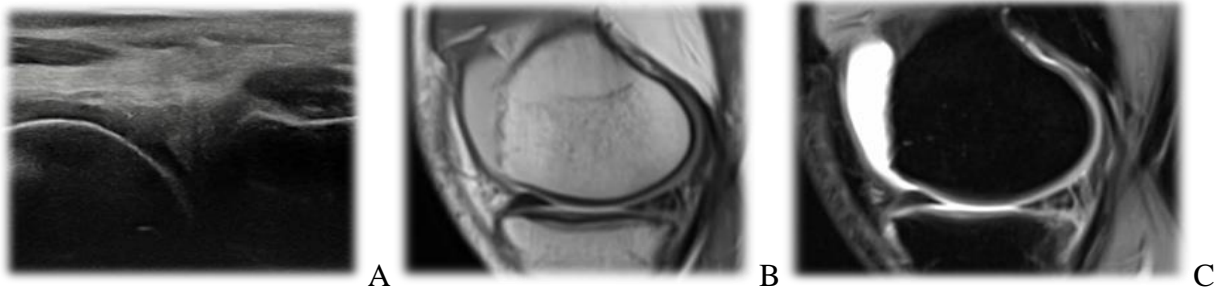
A US images of PHMM tear, B, C MRI images PD and PD fat suppression of PHMM tear.
